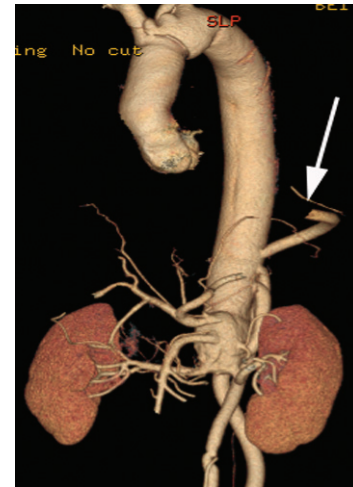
Computed tomography reconstruction showing occluded neo-intercostal artery (arrow).
